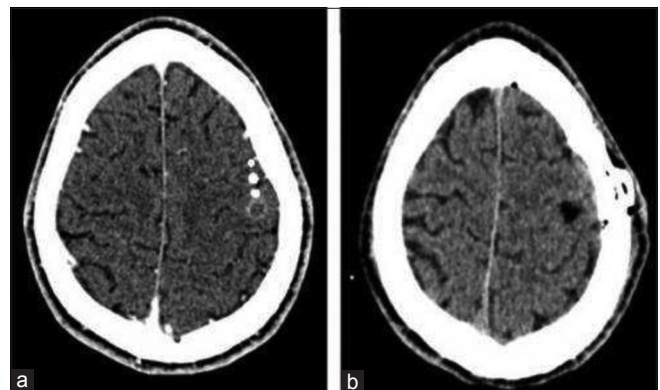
Comparison between preoperative and postoperative head computed tomography. (a) Axial head computed tomography showing the white spots near from lesion area. (b) Postoperative axial head computed tomography with a hypodense image exhibiting a complete lesion resection.
